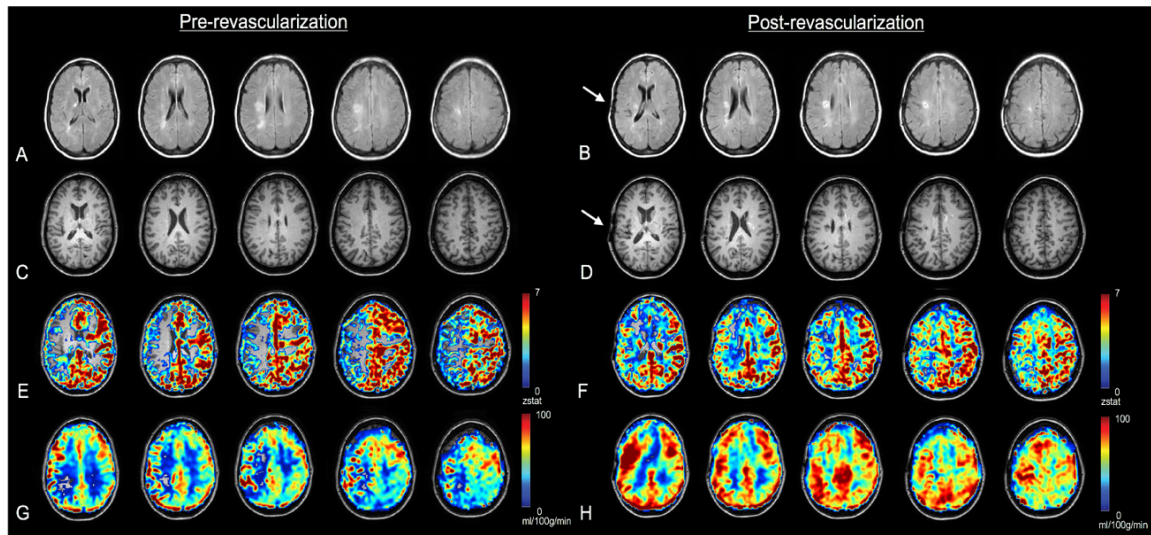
Anatomical and hemodynamic imaging. Imaging was performed before surgical revascularization and one year after surgical revascularization. Axial slices from T_2 -weighted FLAIR (A,B) and axial slices from T_1 -weighted (C,D) are shown pre- and post-revascularization. Structural MRI reveals multiple infarcts in the right hemisphere following infection. Structural MRI findings after surgical revascularization reveal the evolution of the same infarcts, but suggest no new infarctions. Axial slices from CVR-weighted hemodynamic imaging show decreased right-sided reactivity pre-surgery (E), and improvement at follow-up (F). Axial slices from CBF-weighted imaging show decreased blood flow in the right MCA territory pre-surgery (G), and improvement following surgery (H). MRI after surgical revascularization reveal the evolution of the same infarcts, but suggest no new infarction. Arrows denote the site of surgical revascularization.
